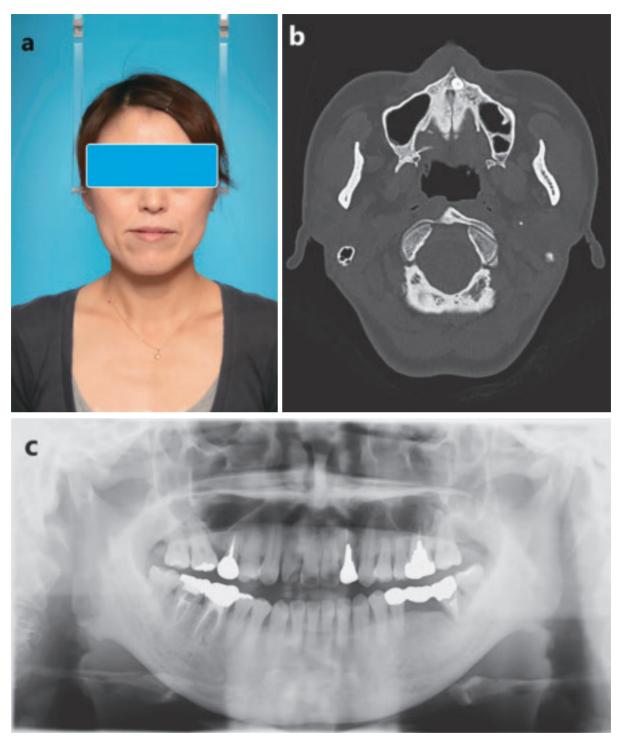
Clinical and Radiological features of the patient. (a) Pre-operative image of the patient showing facial asymmetry due to TMJ disorder. (b) Axial view of the CT showing a hinge-like bony mass arising from the lateral wall of the left maxillary sinus. (c) Panoramic radiogram showing no changes in the left maxillary sinus.
